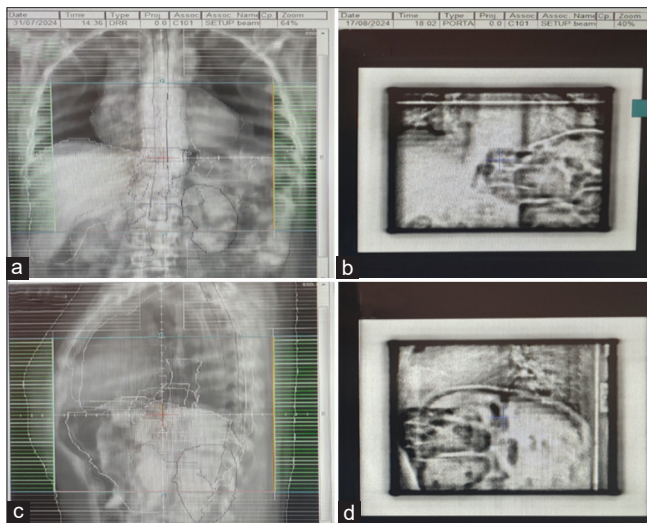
Image from MOSAIC system obtained from treatment planning system (TPS), (a) Anterior to posterior digital reconstructed radiography (DRR) image, (b) anterior to posterior portal image, (c) lateral DRR image, and (d) lateral portal image. DRR images were exported from Monaco TPS, and portal images were taken by Elekta Synergy linear accelerator
